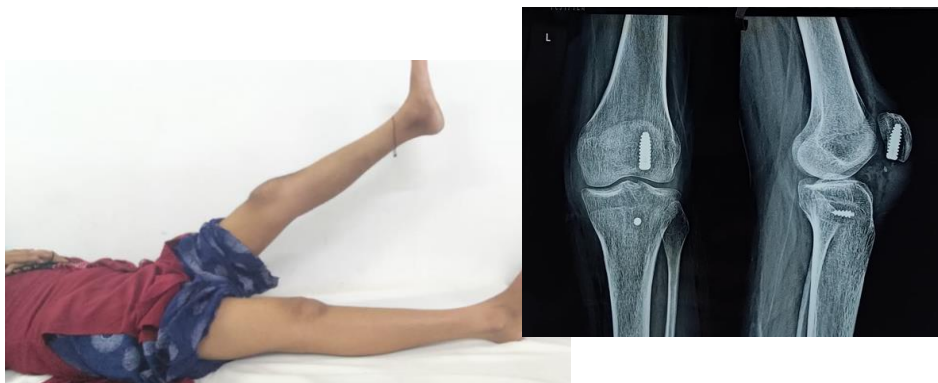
4 months post op range of motion and x-ray
